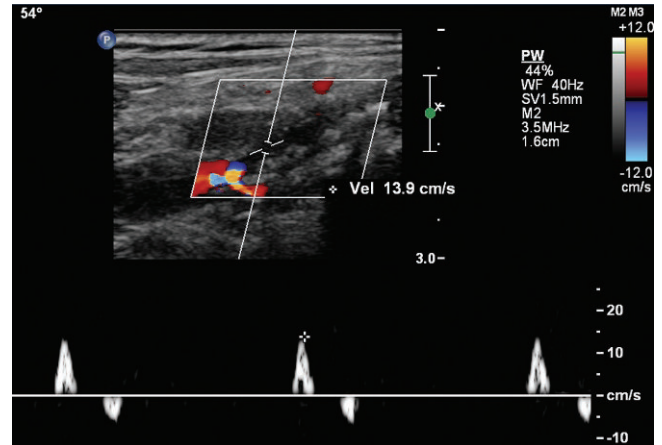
Color duplex Doppler of the popliteal artery shows an abnormal staccato waveform. The forward component has the characteristic shape with a rapid upstroke and immediate downstroke. There is virtually no reverse component. Peak systolic velocity is low, 14 cm/s, and reflects the low flow through the artery at this level. The absence of color in the vessel is a function of the absent flow and, to a lesser degree, attenuation of color signal by the plaque.
